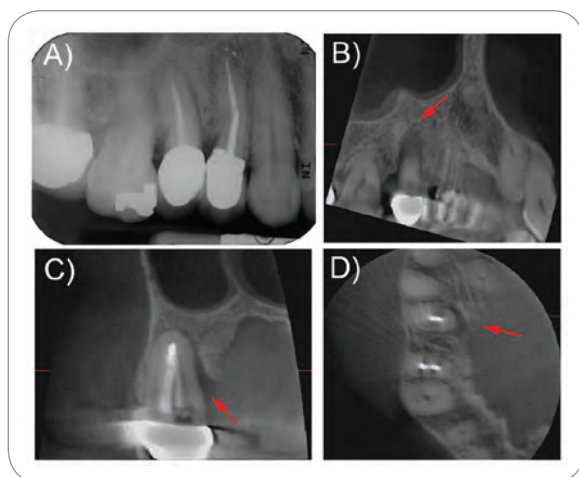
Periapical (A), sagittal (B), cross-sectional (C), and axial (D) CBCT sections of tooth No. 4. Red arrow on CBCT images points to periodontal defect. CBCT images in this and the remaining figures were generated by the limited FOV 3-D Accutomo CBCT scanner by J. Morita.
